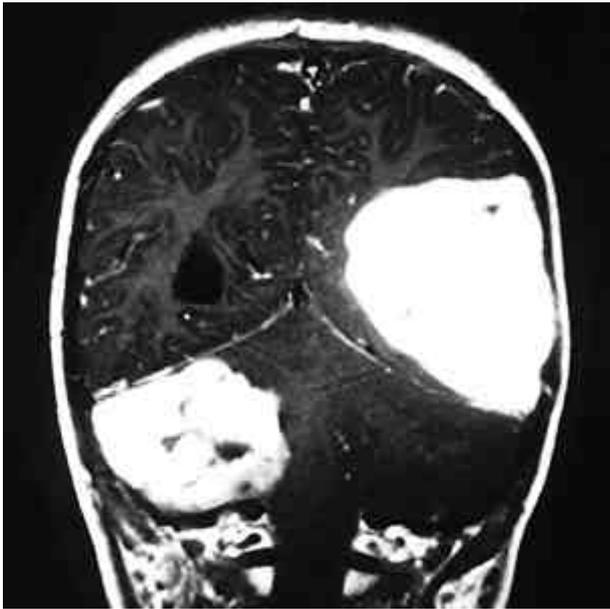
A post-contrast T1 weighted coronal MR image reveals two well-enhancing extraaxial tumor masses on the left parietotemporal area and right cerebellum.
